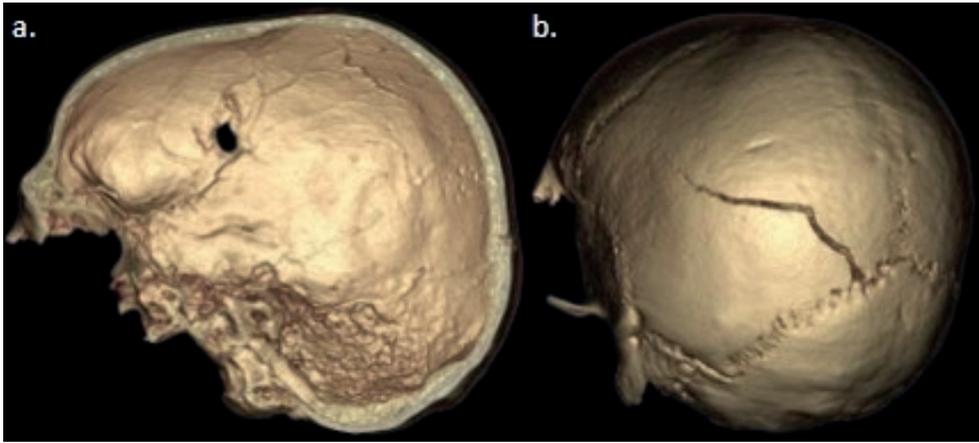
T173 skull computed tomography. a: endocranial, trauma on the right parietal. b: left posterolateral view, fracture lines on the left parietal.
